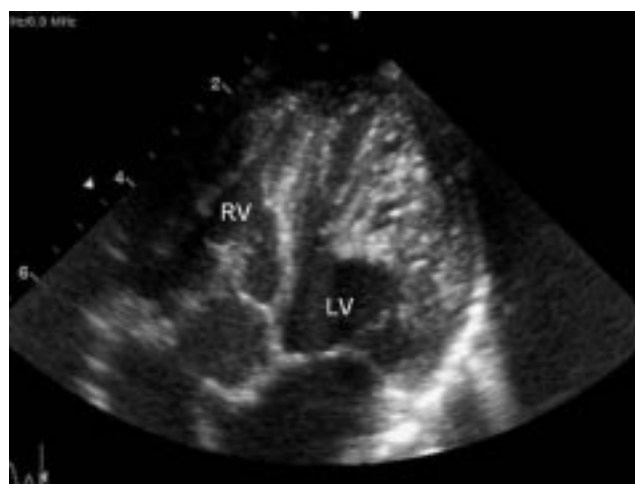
Two dimensional echocardiogram of a patient with left ventricular noncompaction in apical 4-chamber view showing the bilayered arrangement of the myocardium. The inner, thick and hyperechogenic layer is noncompacted, the outer is more echolucent, compacted and thinner than in normal subjects. Trabeculations are prominent and numerous. This appearance is more markedly visible on the lateral wall. LV, left ventricle; RV, right ventricle.
